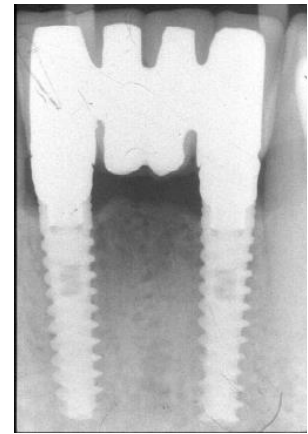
A second periapical impression was performed at the end of the period of follow up.
